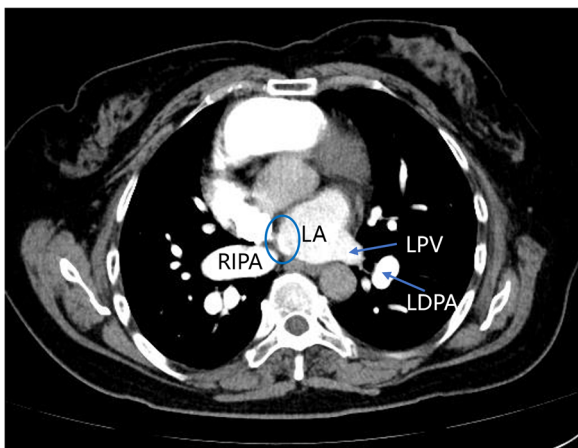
Computed tomography angiography imaging: The image reveals an enlargement of the pulmonary artery and its branches. Notably, the right pulmonary veins are not visualized in their expected location (circled). LA, left atrium; LDPA, left descending pulmonary artery; LPV, left pulmonary vein; RIPA, right interlobar pulmonary artery.
